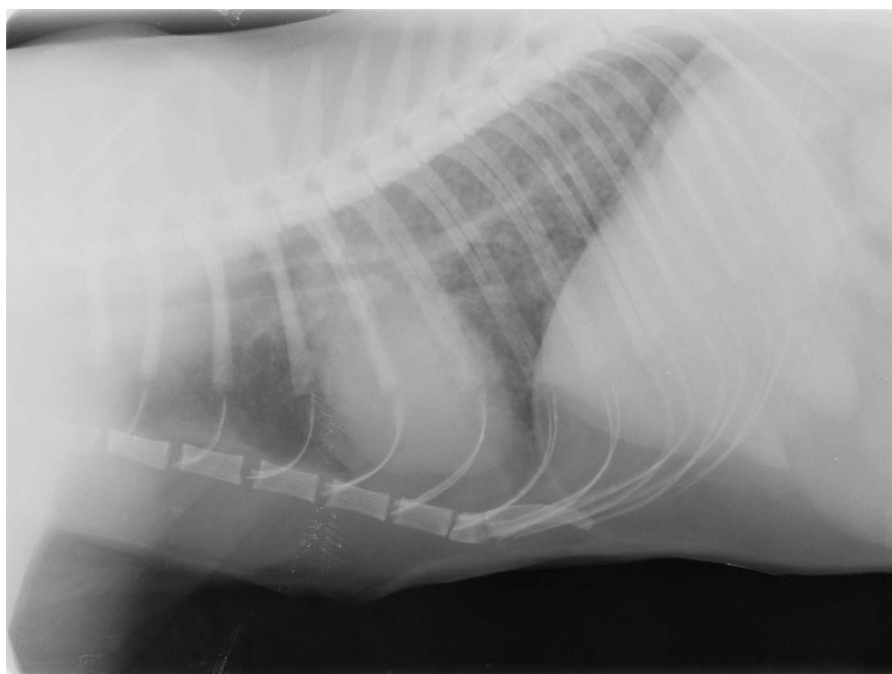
Chest radiograph of patient Z.
